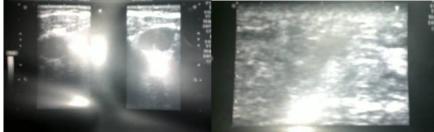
US:focal solid lesion at 3 O'Clock=23x12 mm, speculated margin, architextural distortion, scar tissue is notedthe right images show enlarged axillary LN of metastasis (same case of MRI).
